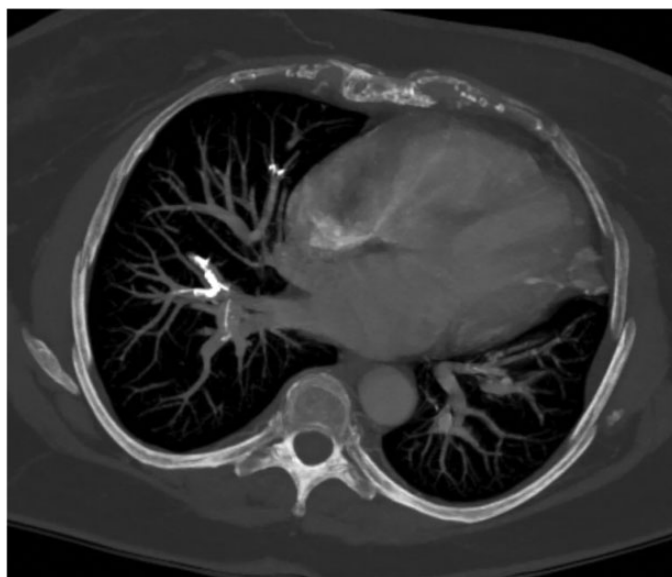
A computed tomography scan shows material with a higher density (depicted in white) than the contrast in various pulmonary arteries. Thrombotic material typically shows a lower density (depicted in black) than the contrast.
